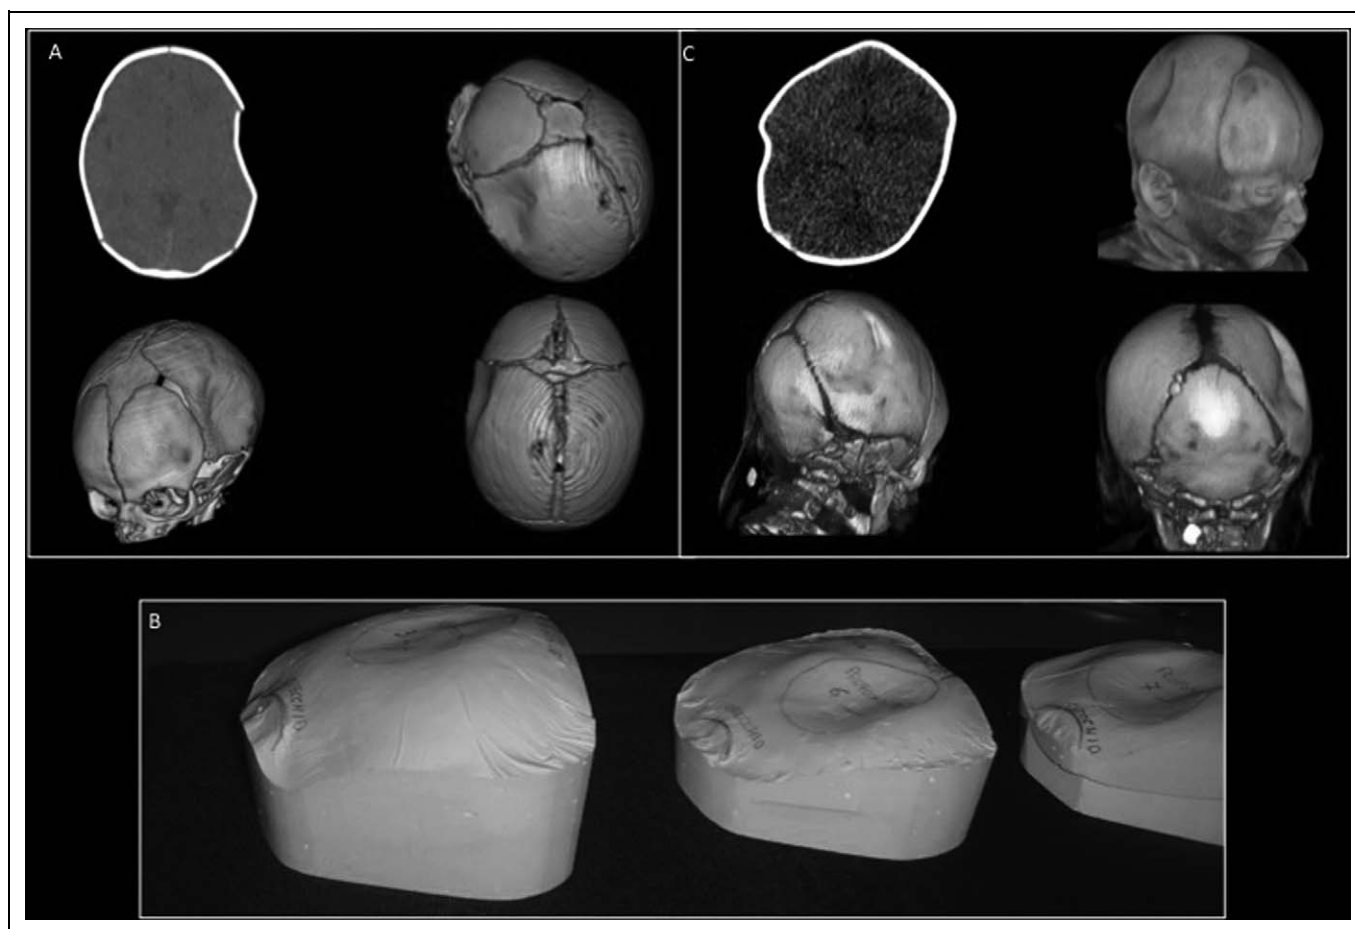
A, Computed tomography (CT) scan with three-dimensional (3D) reconstruction of a large left parietal skull depressed fracture. B, Plaster cast measuring the skull depression was applied to the child's head every 2 months giving parents the opportunity to appreciate the resolution (from right to left) of the deformity. C, CT scan with 3D reconstruction of a large right posterior parietal skull depressed fracture.
